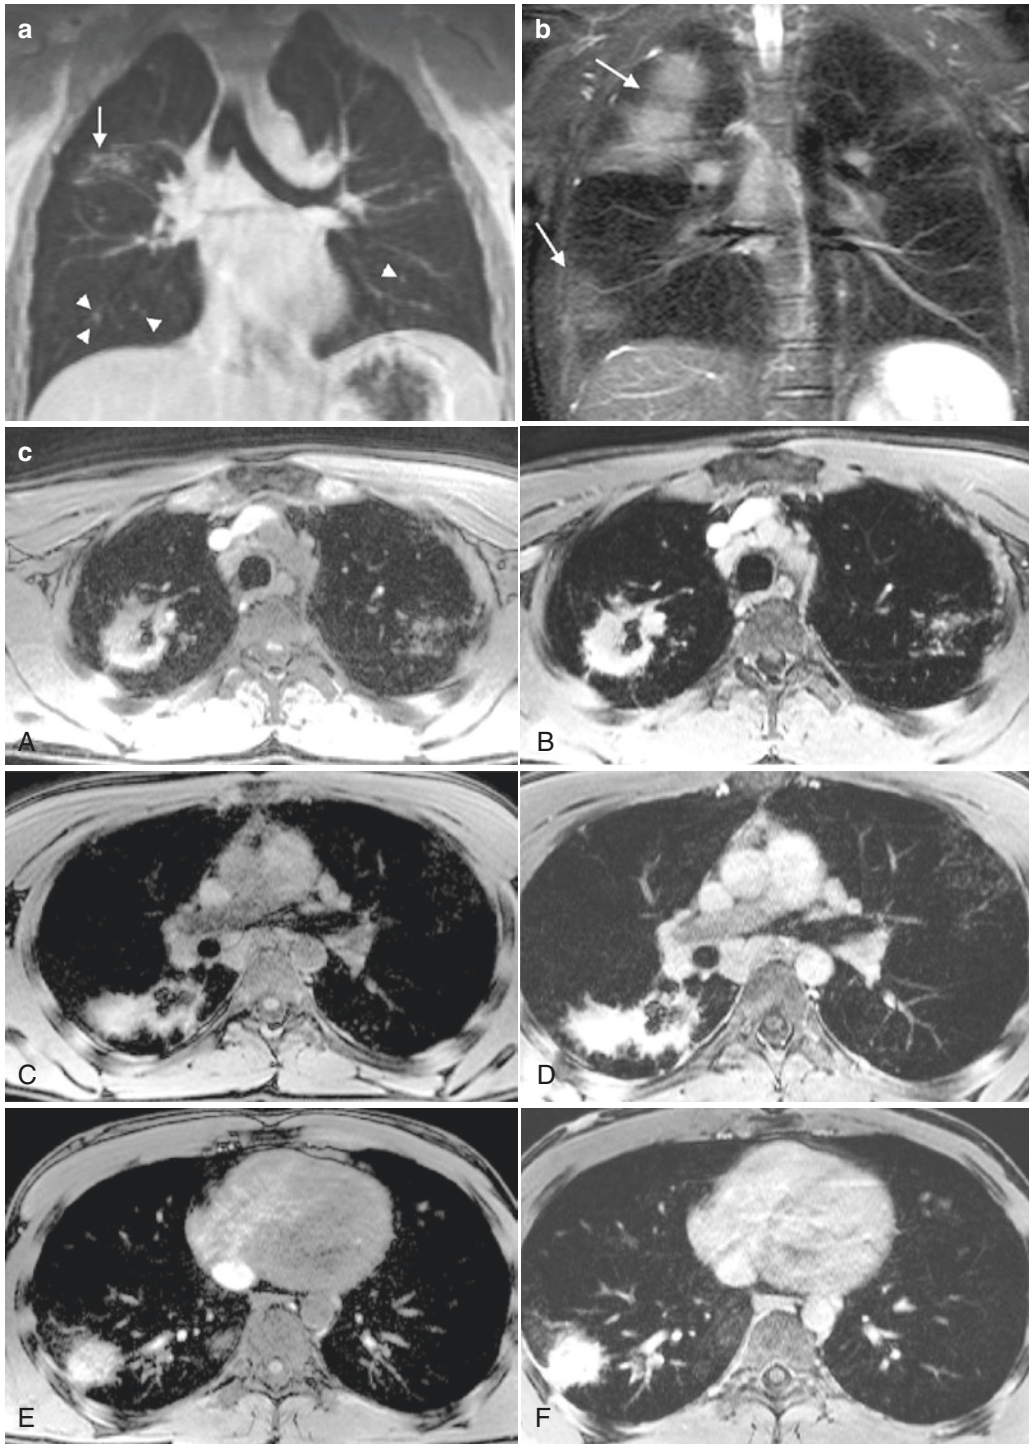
(a–d) A 26-year-old male patient with sarcoidosis. (a) Post-contrast T1-weighted 3D FLASH coronal image displays peribronchovascular thickening (*arrow*) and nodularity (*arrowheads*). Note mediastinal lymphadenopathy. (b) IR-HASTE (inversion recovery half-Fourier acquisition single-shot turbo spin-echo) coronal image shows areas of consolidation (*arrows*). (c) Pre- (A–C) and post-contrast (D–F)
